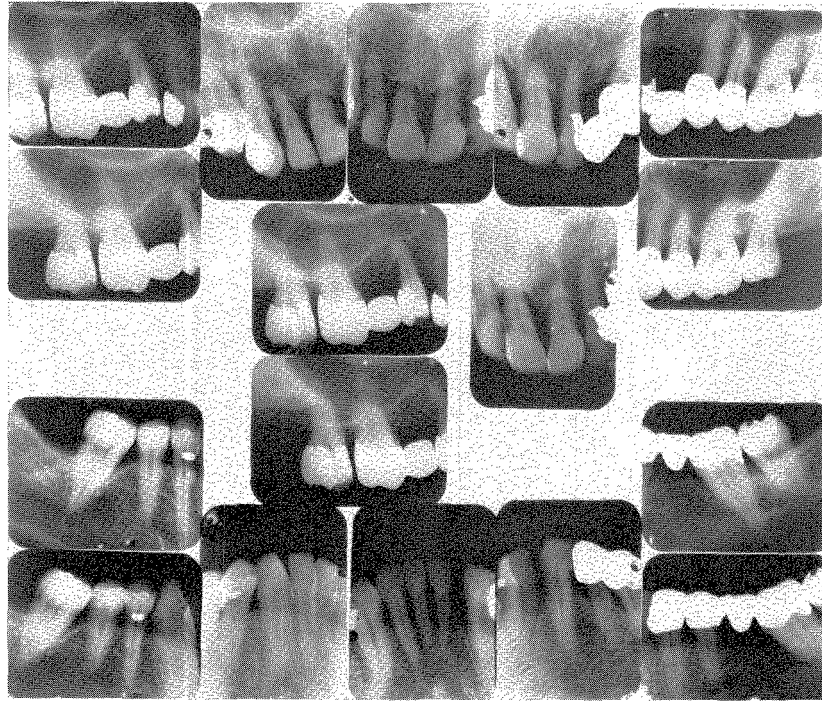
Roentgenograms taken in 1952 at the start of treatment. Observe the small amount of supporting bone remaining around the upper incisors.
